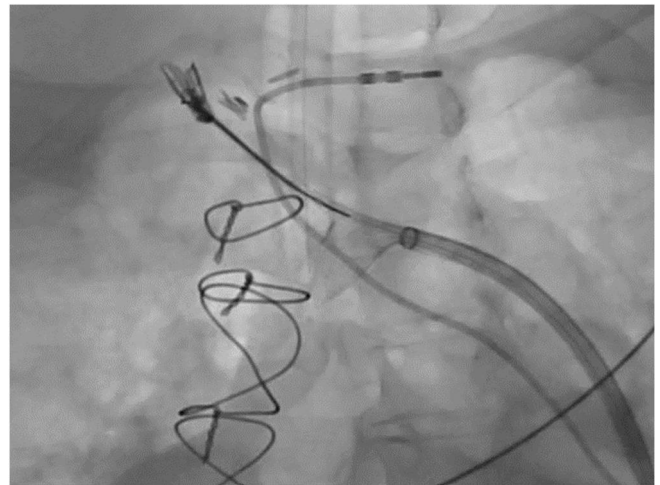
Embolized MitraClip in the chest X-ray.
